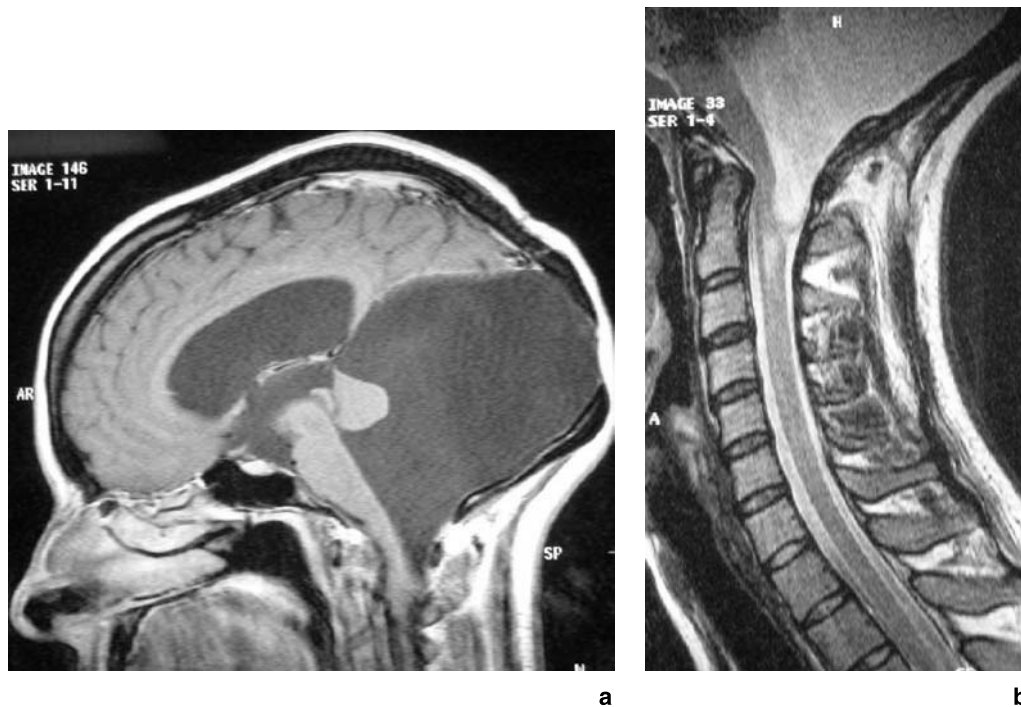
(a) T1-weighted sagittal MR image showing a large posterior fossa cyst consistent with a Dandy-Walker malformation. The inferior aspect of the cyst herniates through the foramen magnum causing a type of Chiari malformation. (b) T2-weighted sagittal MR image showing the herniated Dandy-Walker cyst at the foramen magnum. There is a small upper cervical syrinx
